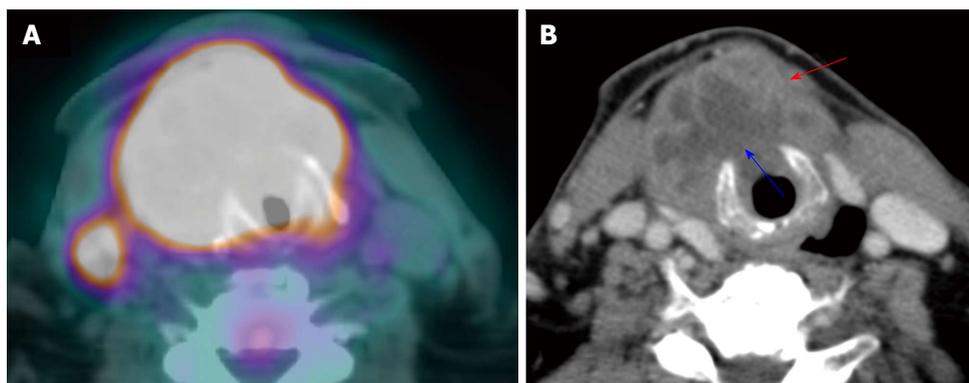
Laryngeal cartilage invasion. A large T4a squamous cell carcinoma of the larynx with through-and-through cricoid cartilage invasion (blue arrow) and extralaryngeal invasion (red arrow) demonstrated on both positron emission tomography/computed tomography (CT) (A) and contrast-enhanced CT (B).
